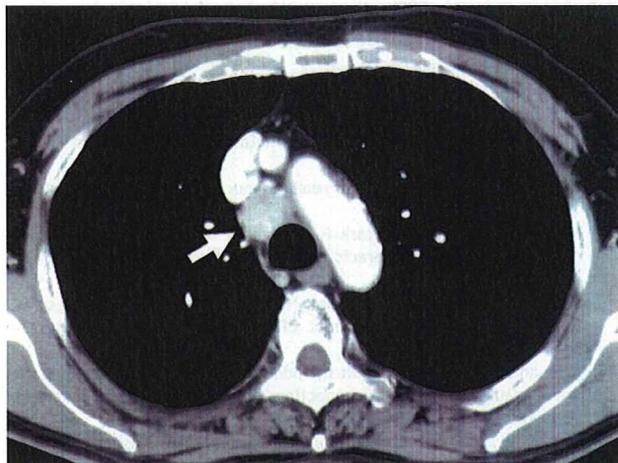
A contrast-enhanced chest CT-scan showed an anterior mediastinal mass measuring 2 cm that is well enhanced (arrow).
